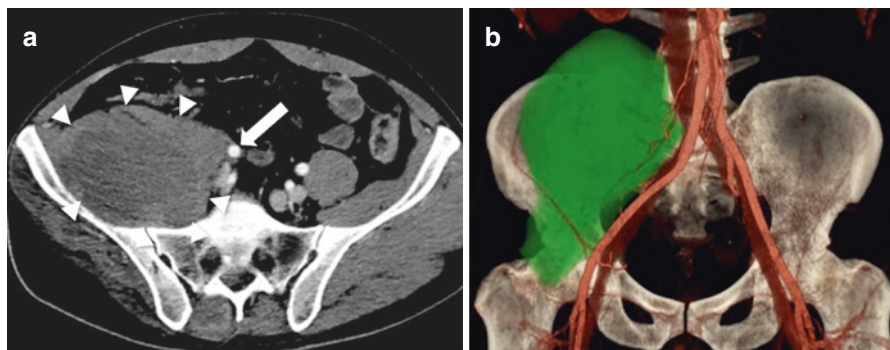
CTA of a patient with a pelvic malignant peripheral nerve sheath tumor (arrowheads). (a) The proximity of the tumor with the external iliac artery is well demonstrated (arrow). (b) 3D reconstruction showing the relation of the tumor with iliac veins and arteries important for surgical planning
